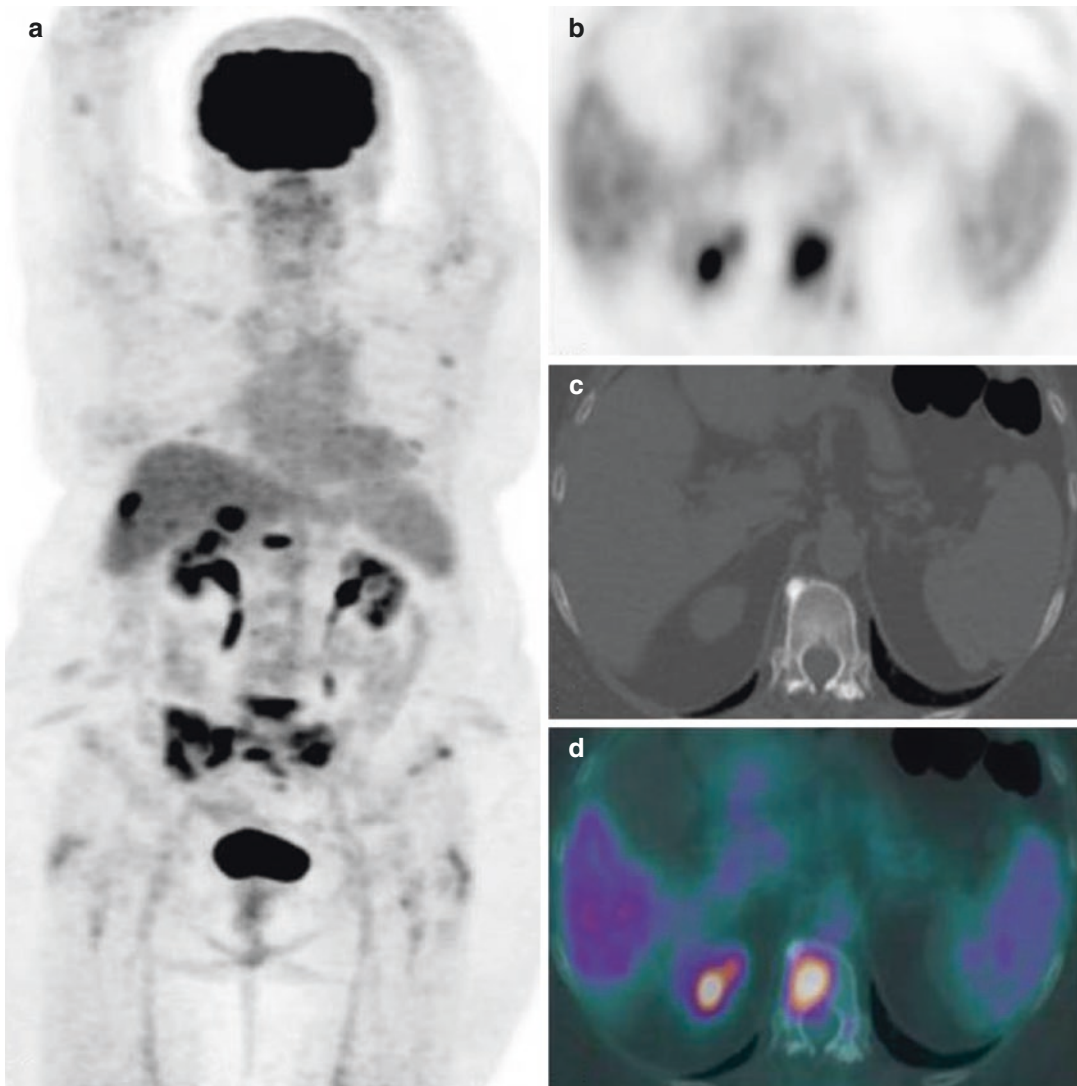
^{18}F -FDG PET 3D maximum intensity projection (a) shows several bone metastases and a hepatic lesion in a 61-year-old woman examined for restaging
